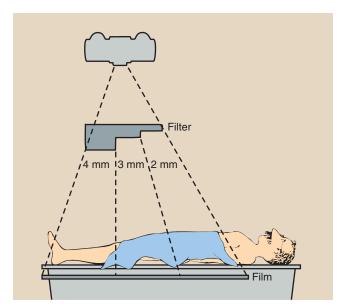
Arrangement of apparatus with the use of an aluminum step-wedge for serial radiography of the abdomen and lower extremities.
